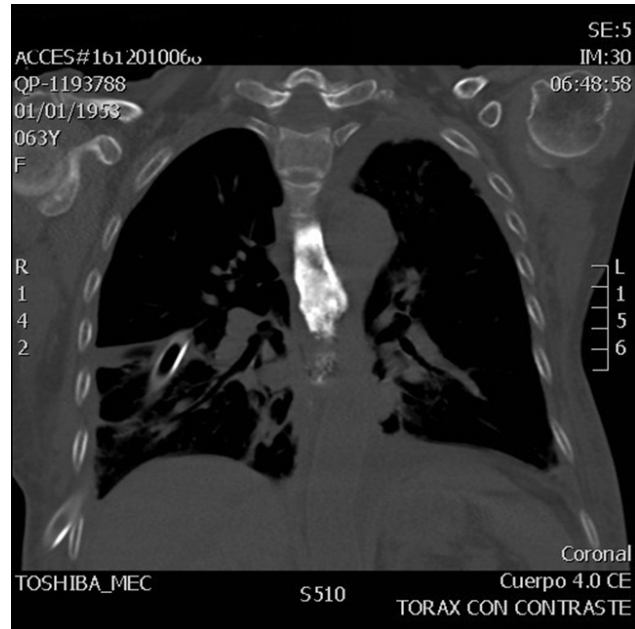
CT Scan of the patient with oral contrast which show the site of stenosis in the middle third of the esophagus
